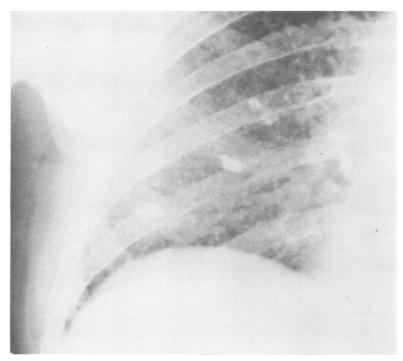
Radiographic appearances in right lower zone of case 9, who worked as a helper or deseamer for 14 yr, mainly on the special steel ingots. No other relevant occupational dust oxposure. ILO pneumoconiosis category 3.
